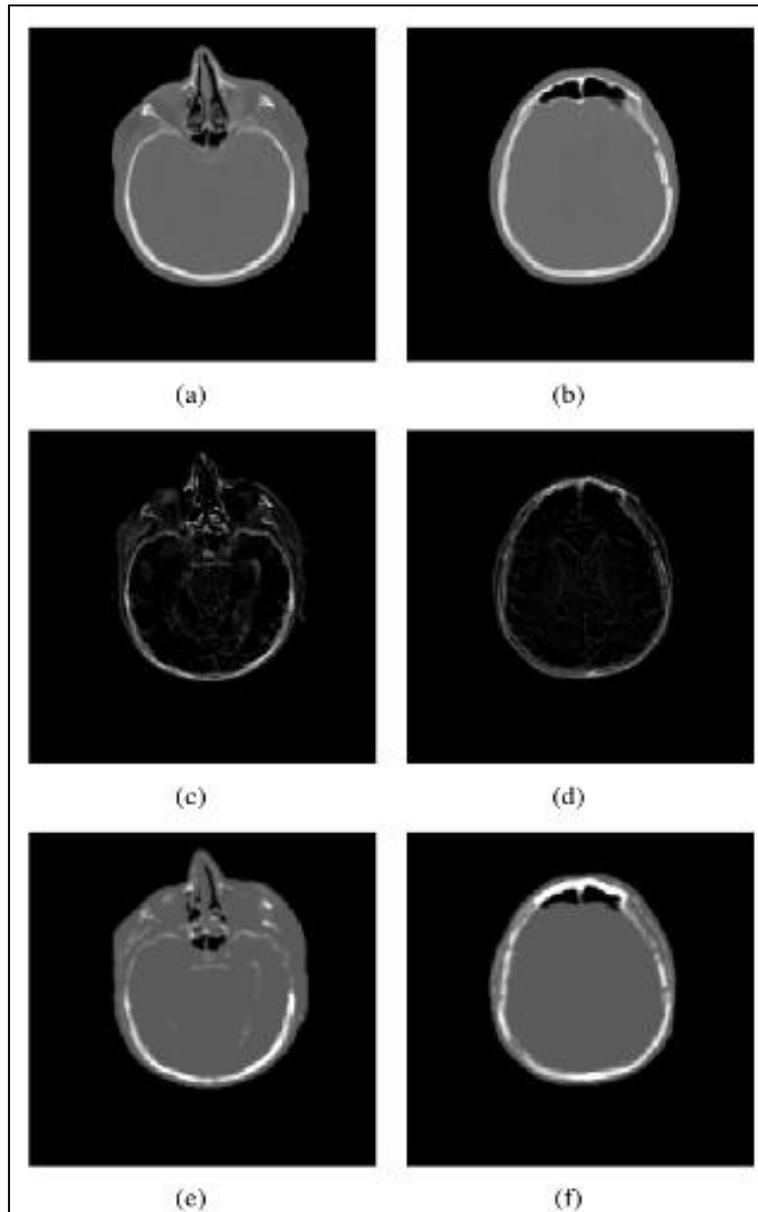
CT (a,b), R2 map (c,d) and MR-based  $\mu$ -map (e,f) of two representative axial slices.
